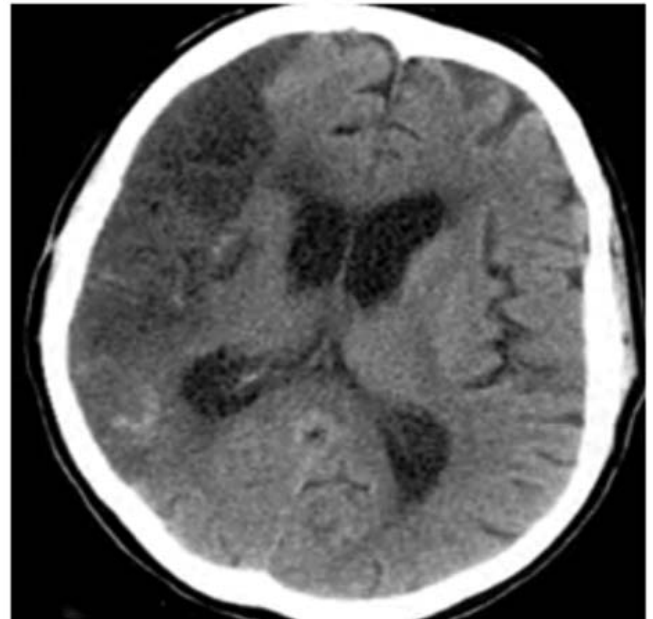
CT- scan of brain (Acute Ischemic Stroke) Pt's name: Mr. Mozibur Age: 52.
